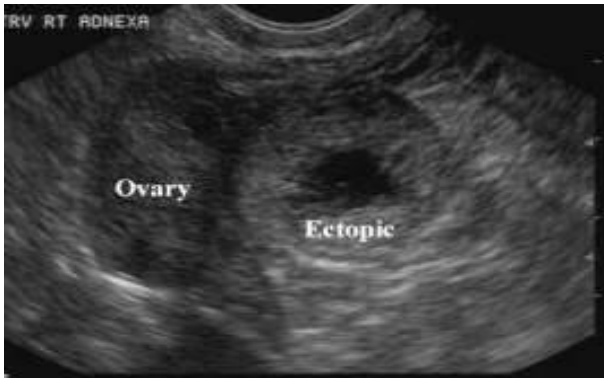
TAS & TVS BOTH shows empty uterus with a echogenic complex mass (chronic) not showing ring of fire on color Doppler. Normal right ovary seen adjacent to complex mass.
